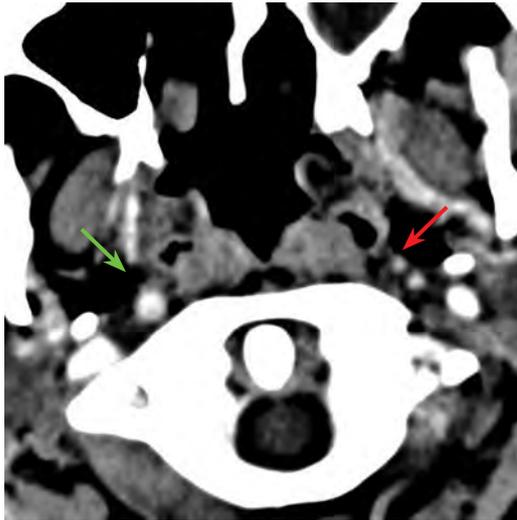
The axial contrast enhanced CT scan shows a hypoplastic cervical segment of the left internal carotid artery (red arrow) in relation to the diameter of the right ICA (green arrow).
